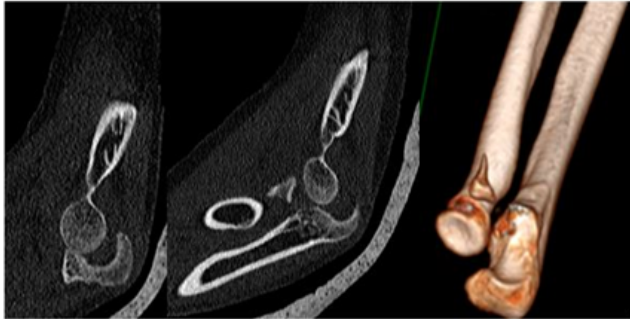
Two dimensional and three-dimensional computed tomography images of the patient's left elbow demonstrate the loss of the anterolateral aspect of the coronoid process with associated posterior subluxation of the humeroulnar joint.
